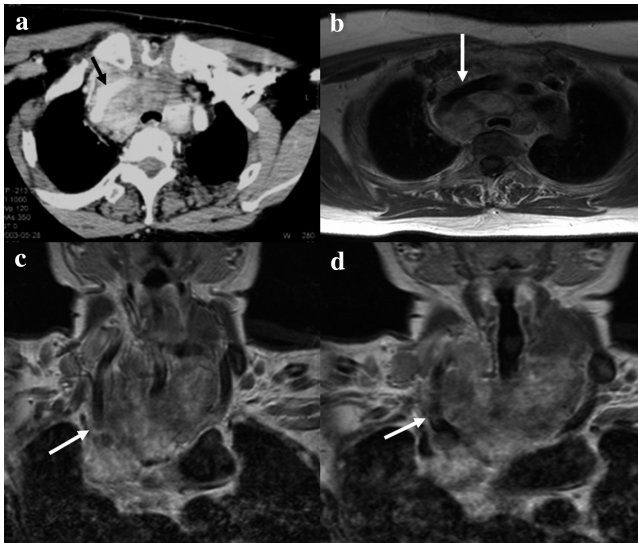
Preoperative computed tomography (a) and magnetic resonance imaging (b–d) showed the tumor encasement of great vessels of the neck including right common carotid artery (c, d) and brachiocephalic trunk (a, b).
